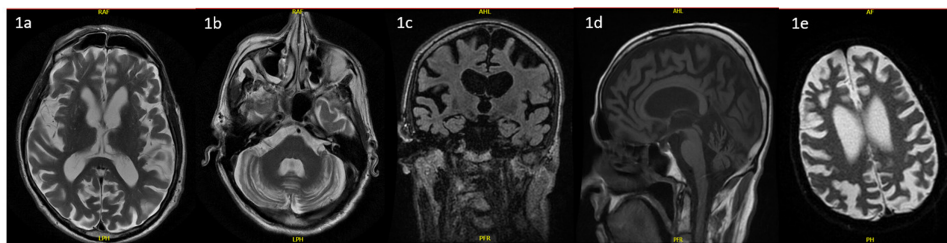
T2 axial (1a, 1b, 1e), T2 coronal (1c) and T2 sagittal (1d) MRI brain images of the patient, showing cortical, cerebellar and caudate atrophy.
